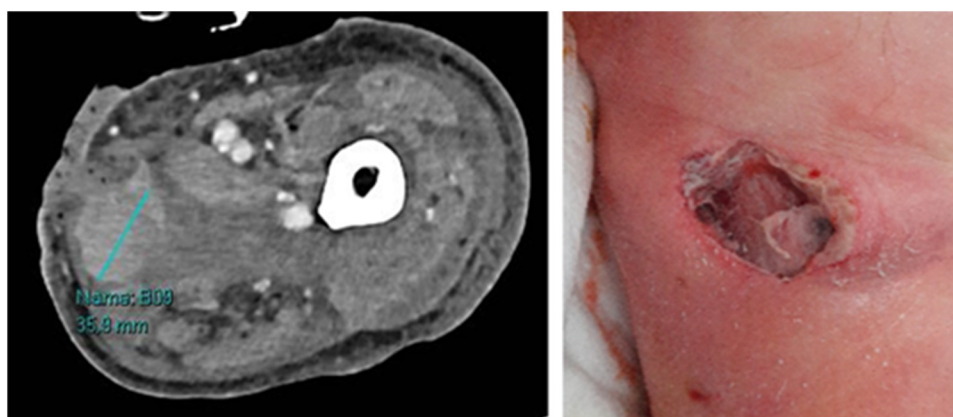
CT scan showing subcutaneous hematoma (left) and incision showing no necrosis of fascia or muscle tissue (right).
